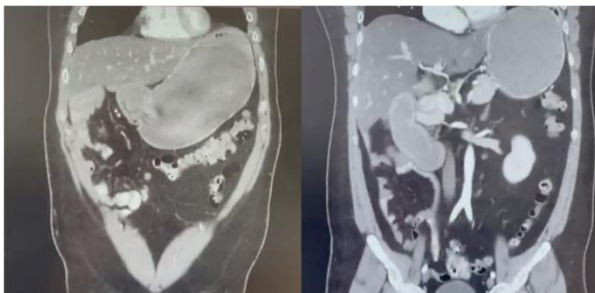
New CT scan was performed showing dilatation of the gastric chamber and duodenum apparently up to the third part with a transition zone without being able to visualize the etiology, with contrast medium advancing to the sigmoid colon.
